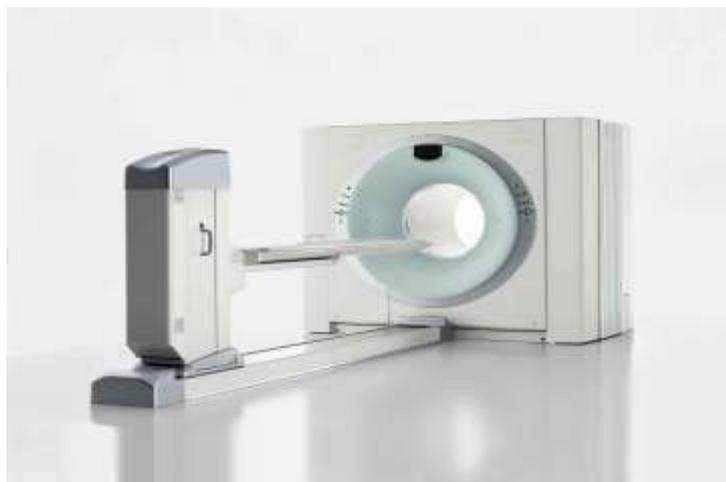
PET-CT Instrument
